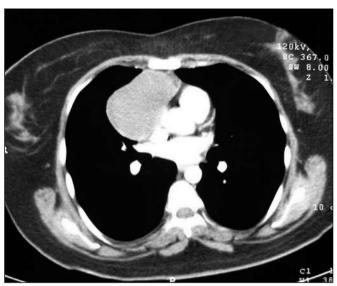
Thorax CT showing mass lesion 7x9 cm in diameter located in the anterior mediastinum
